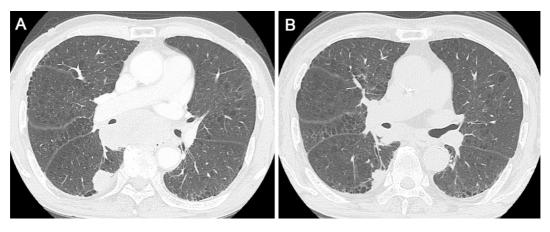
Computed tomography findings of the chest before pembrolizumab treatment (A). A mass can be observed in the right lower lobe of the lung. Mediastinal lymphadenopathy markedly regressed after glucocorticoid treatment for autoimmune hemolytic anemia and hemophagocytic lymphohistiocytosis as complications of pembrolizumab on day 73 after the first dose (B).
